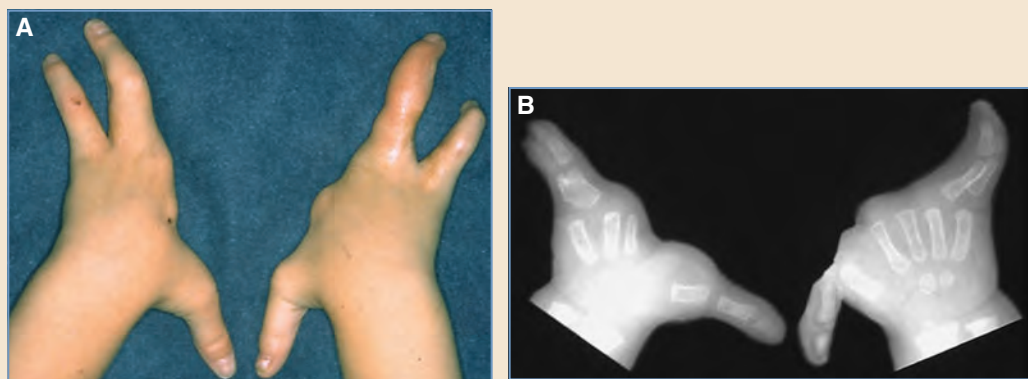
Cleft hand. A, Clinical appearance and B, radiographs of both hands in this 4-year-old child show unstable thumbs at the MP joint level. Despite the wide central cleft and the absence of index and long digits, the child's function was remarkably good. Subsequent surgery consisted of ulnar collateral ligament reconstruction of both thumbs and a camptodactyly release on the right ring digit.
